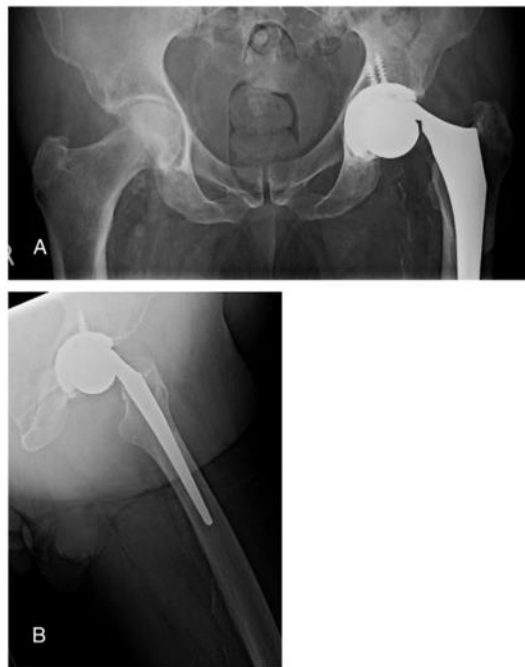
(A) and (B) Initial radiographic images on presentation (patient 2) showing dissociation of the trunnion from the femoral head.
